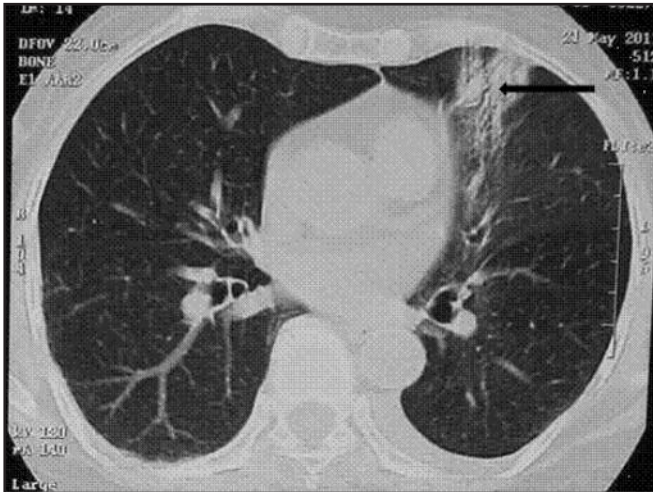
Computed tomography of chest showing interstitial infiltration of the anterior segment of the left upper lobe (arrow).
